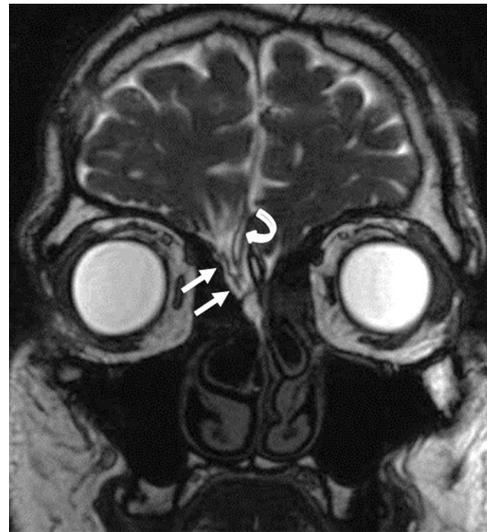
Forty-five-year-old woman with watery nasal discharge on right side, 4 years post-road traffic accident. Coronal FIESTA MR image shows defect in right cribriform plate (arrows) with herniation of gyrus rectus and adjacent gliosis (curved arrow).
